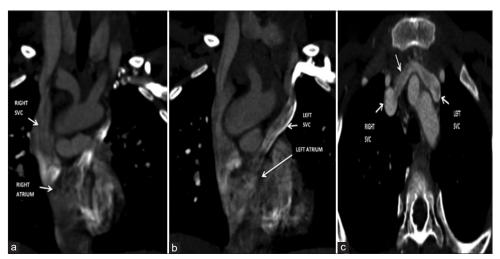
Double superior vena cava. (a) coronal computed tomography (CT) pulmonary angiogram images showing the right superior vena cava draining into the right atrium; (b) coronal CT pulmonary angiogram images showing the left superior vena cava draining into the left atrium; (c) axial CT pulmonary angiogram images showing the connection between the right and left superior vena cava
